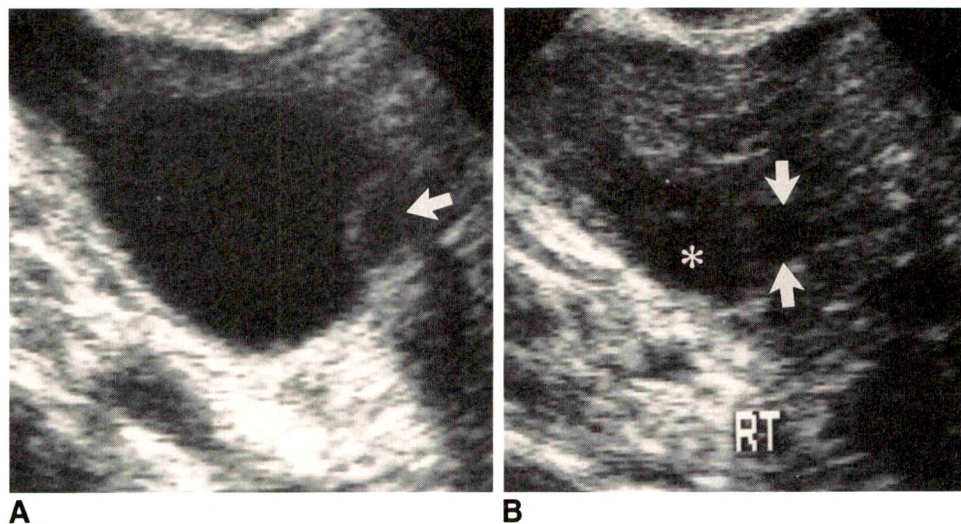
Serial sonograms show slice-thickness artifact mimicking a cumulus oophorus. This eccentric adjacent follicle is present before and after ovulation and is clearly not a cumulus.
